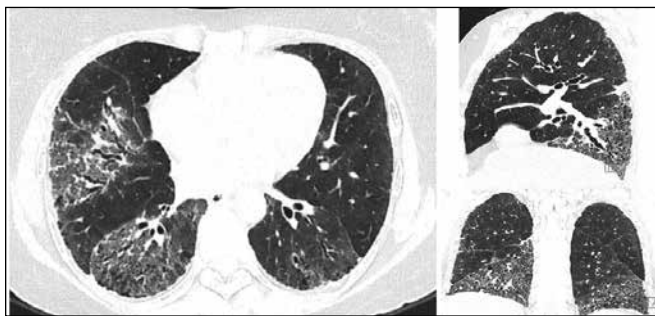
A 45-year-old female with a diagnosis of systemic sclerosis. HRCT(axial, sagittal and coronal reformatted images) showing peripheral and basal predominant GGO with intra- and inter-lobular septal thickening and traction bronchiectasis suggestive of NSIP.
